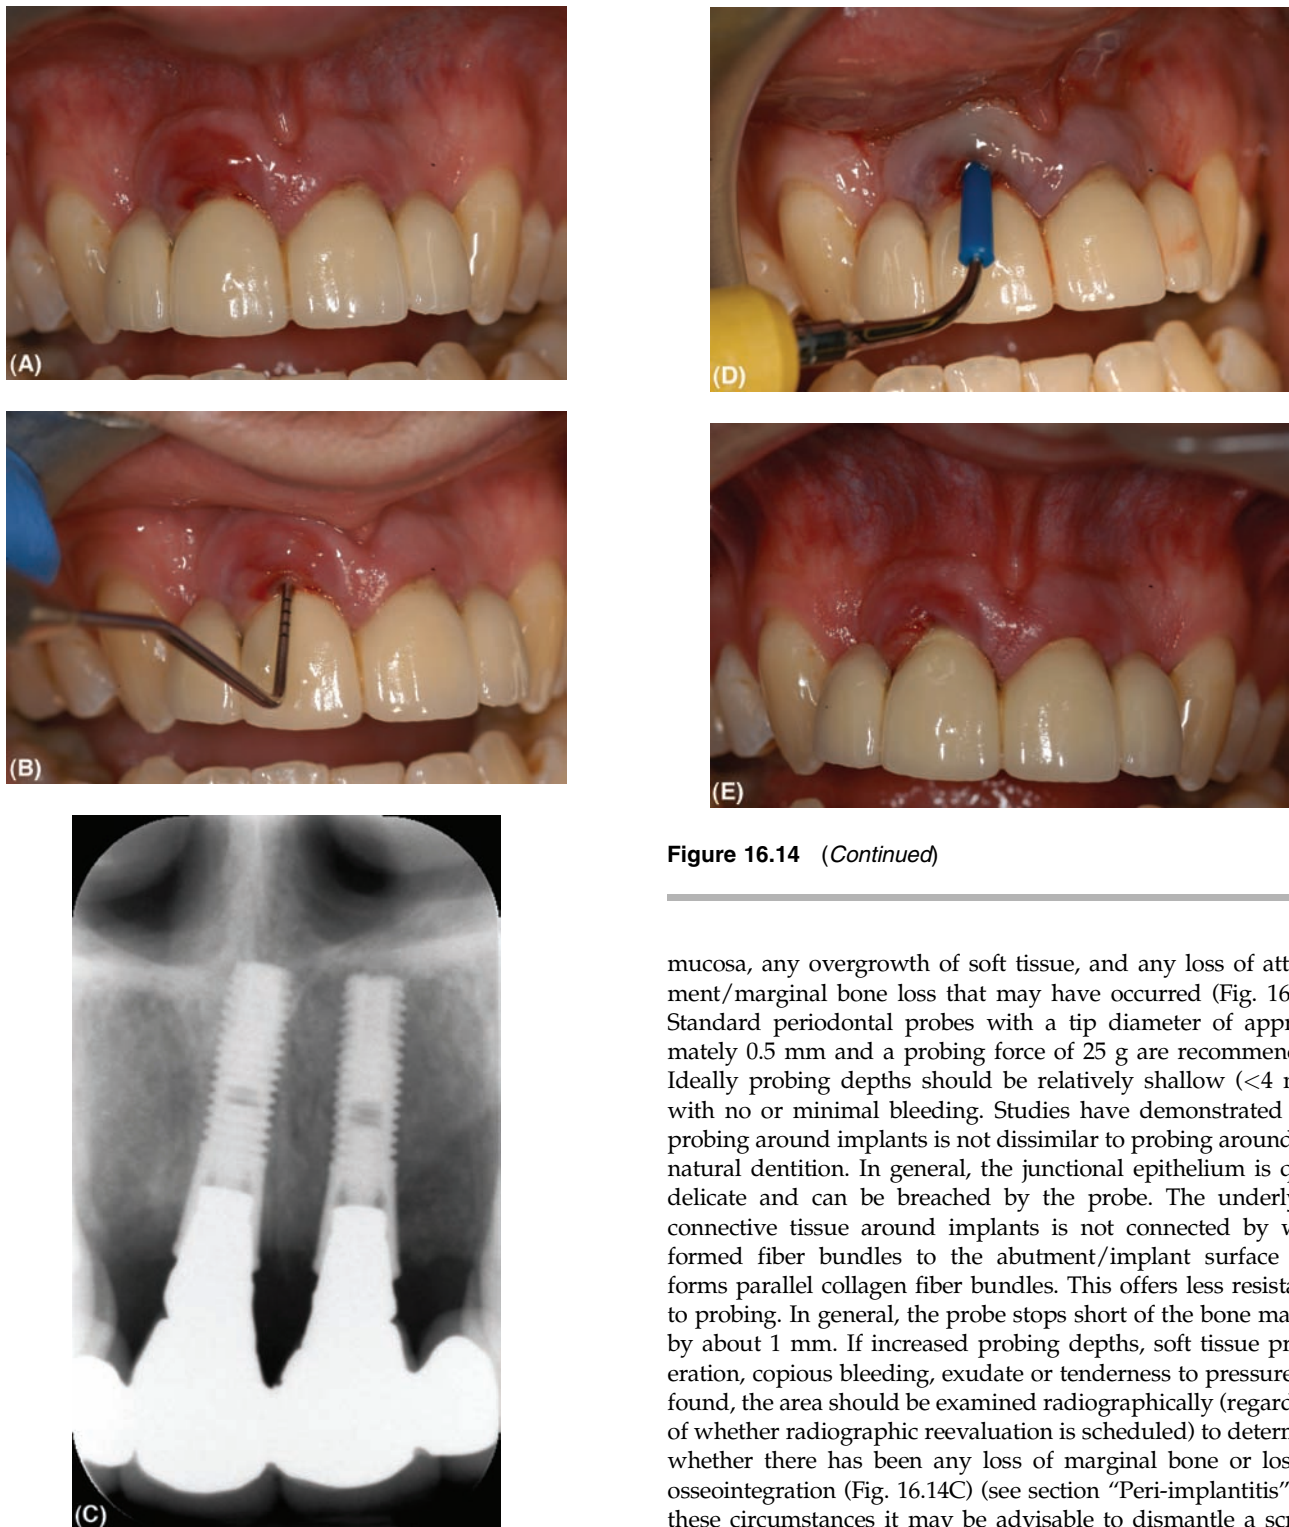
(A) Severe soft tissue inflammation associated with the implant at UR1. (B) A mid-labial probing depth of 6 mm is recorded. (C) A periapical radiograph of the implant bridge. This demonstrates that there has been some bone loss (approximately 2 mm) associated with the right implant. Apical positioning of the implants and the long abutments account for much of the increased probing depth. (D) An ultrasonic scaler with a plastic tip is used to debride the abutment surface. (E) Two weeks after debridement there has been some improvement in the soft tissue inflammation but further treatment is required.
